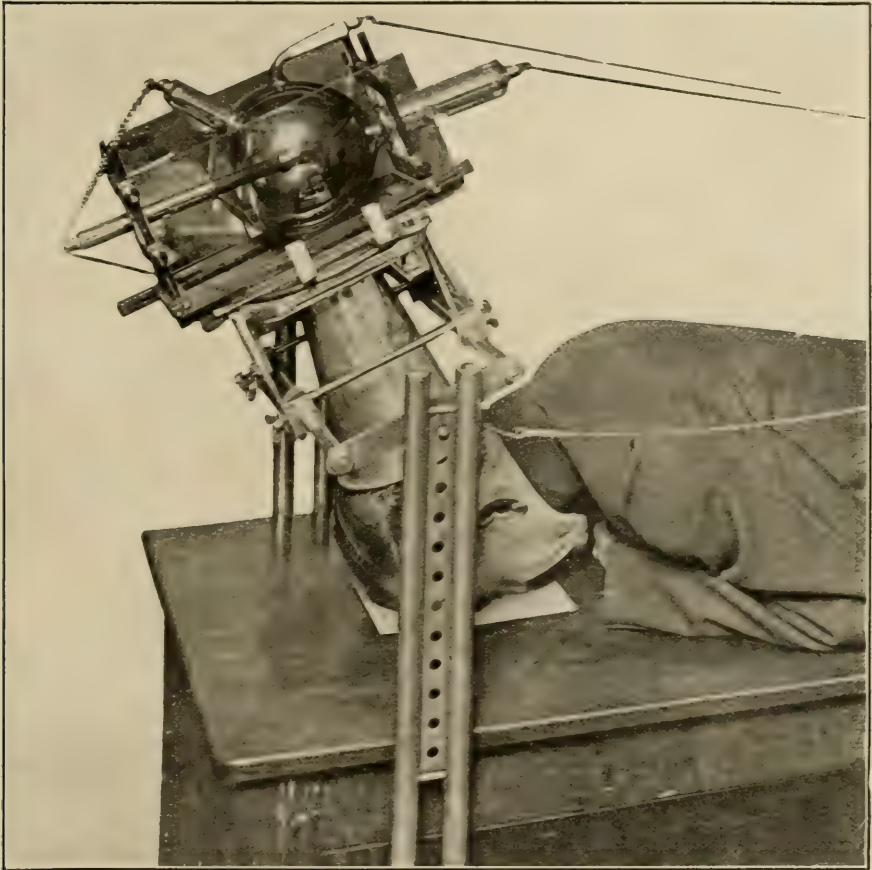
Pose for making radiographs of the Antra of Highmore.
